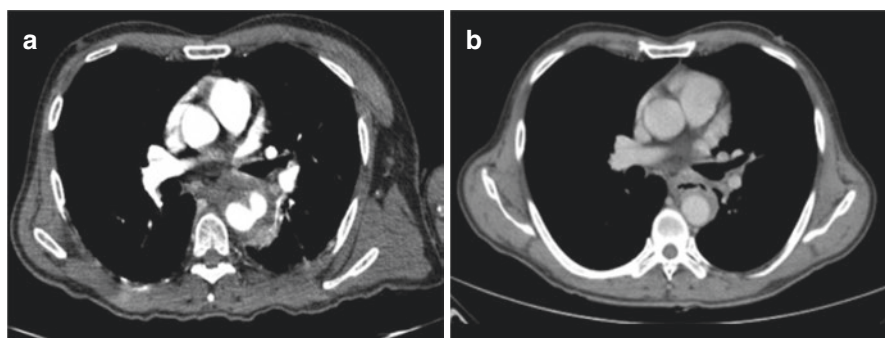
Thoracic computed tomography staging in esophageal carcinoma. (a) Thoracic esophageal carcinoma involving thoracic aorta and causing aortic dissection. (b) Esophageal carcinoma involving thoracic aorta more than 180°
